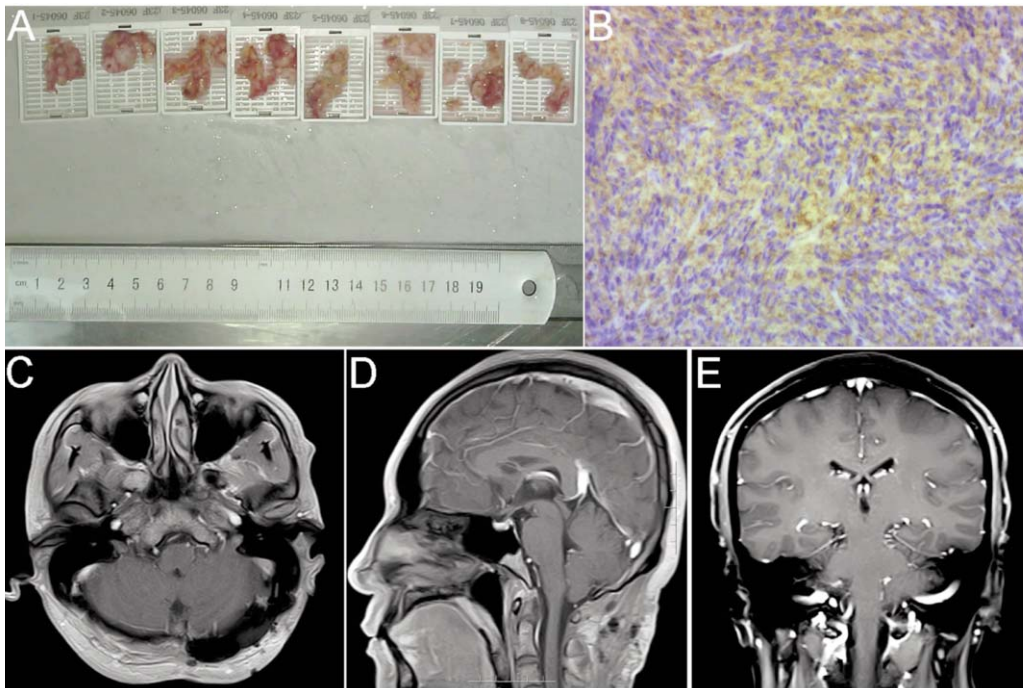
Post-operative pathological and imaging findings. (A) The tumour tissue is removed during surgery. (B) Pathological results suggest a nerve sheath tumour. (C–E) Cranial magnetic resonance imaging performed three months later shows that the tumour has been completely removed without a remnant.
